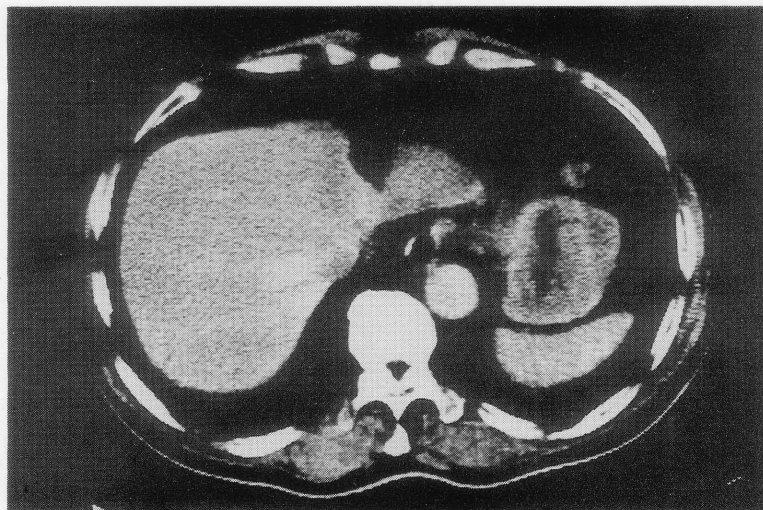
CT shows a diffuse thickening of the gastric wall.
